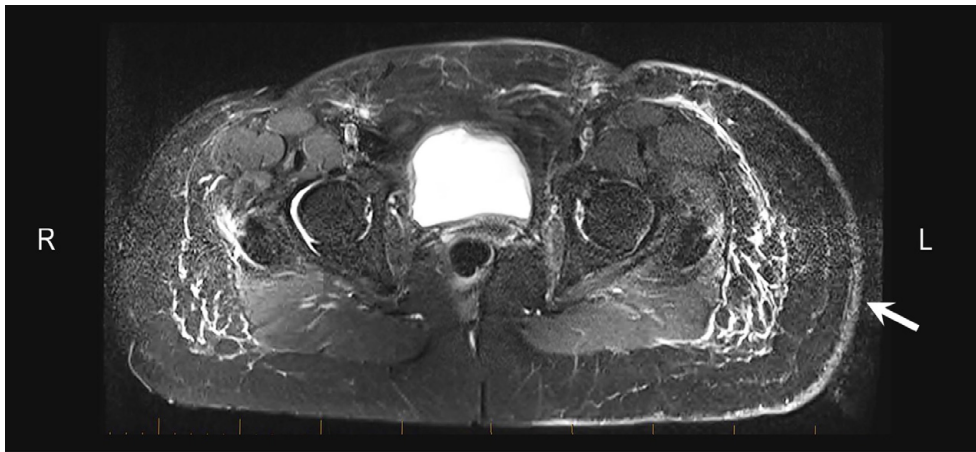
MRI image of a patient with left sided lymphoedema and increased signal intensity in the skin on the left side (arrow) (Karlsson *et al.*, 2022c).
